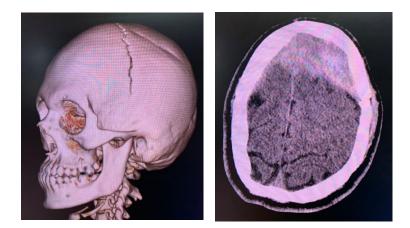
Case 1. CT skull scan in coronal section with epidural image and linear fracture tracing partially followed by partially disconnected coronal suture.
